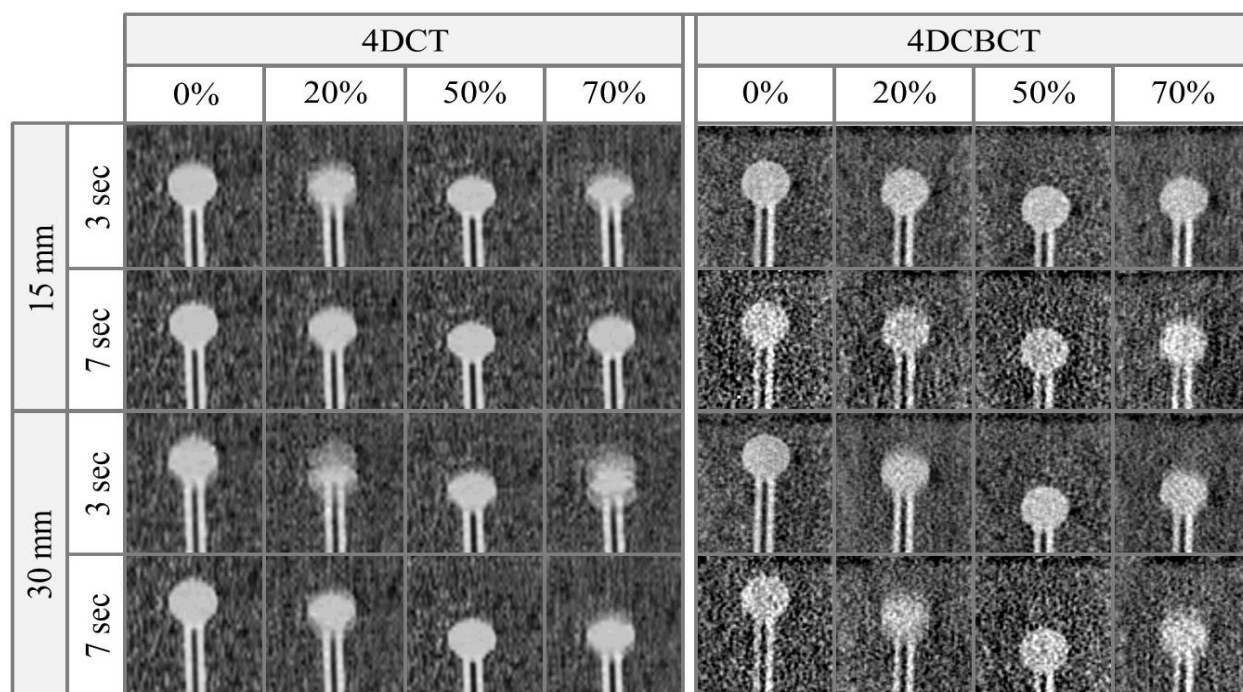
Representative 4DCT and 4DCBCT phase images for inhale (0%), exhale (50%), and intermediate (20%, 70%)
